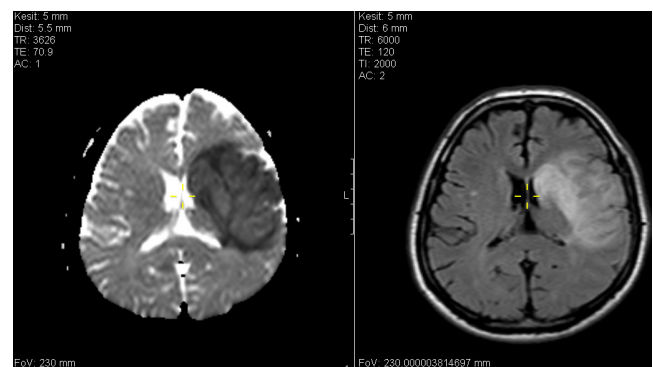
Cranial MRI image
